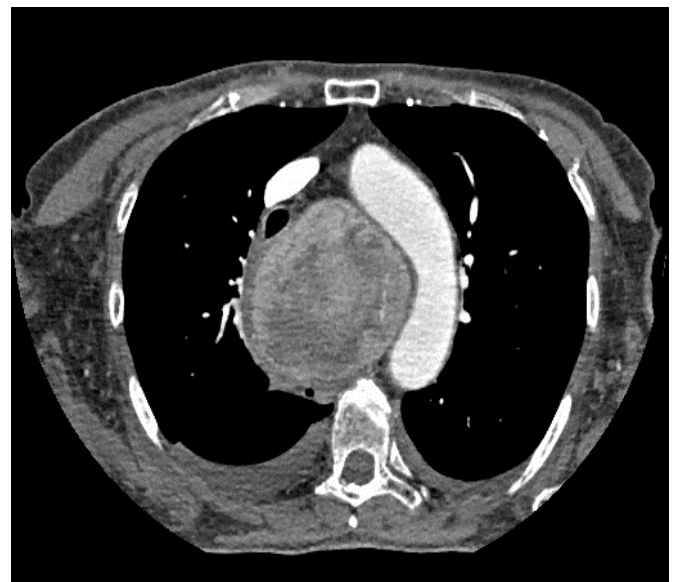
Preoperative sagittal CT scan.
